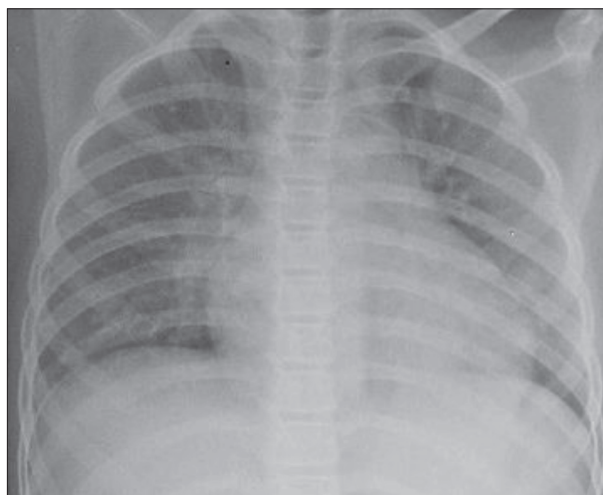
The chest X-ray of the 11-year-old girl with multisystem inflammatory syndrome associated with COVID-19 bilateral ground glass opacities
